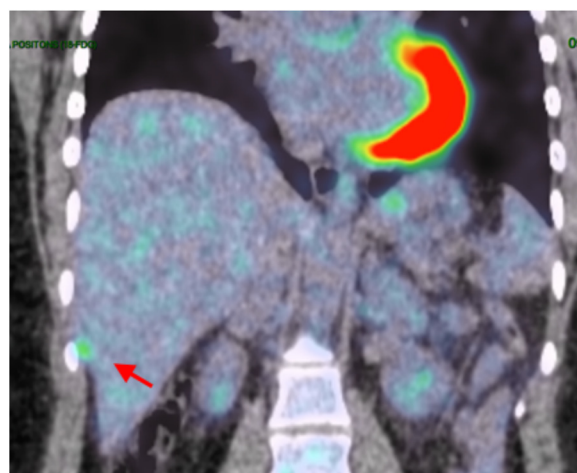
FDG-uptake of segment VI lesion.
